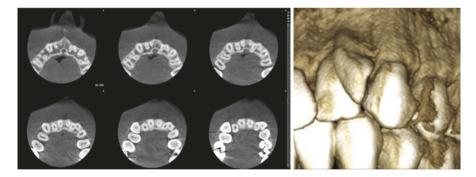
This small-field-of-view cone beam computed tomography of the left-hand-side permanent maxillary lateral incisor, which clinically appeared to have a double crown or to be a dens evaginatus (see Sect. 7.6), shows that the tooth is actually a gemination with fused pulp systems
